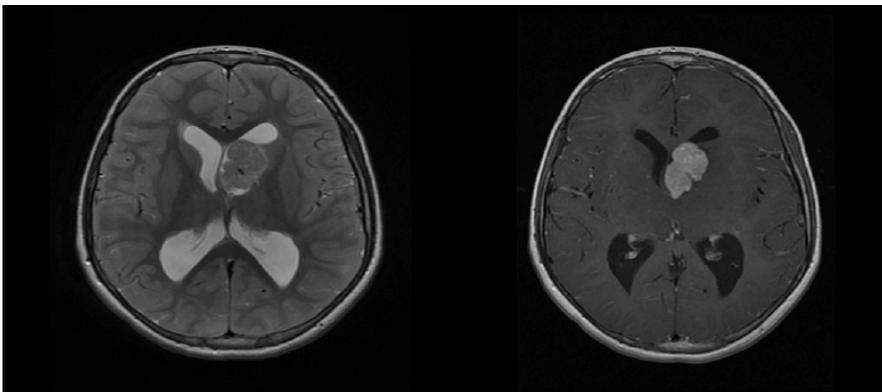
Brain MRI of 11-year-old boy presented to the Pediatric Neurology Clinic for evaluation of seizures.
